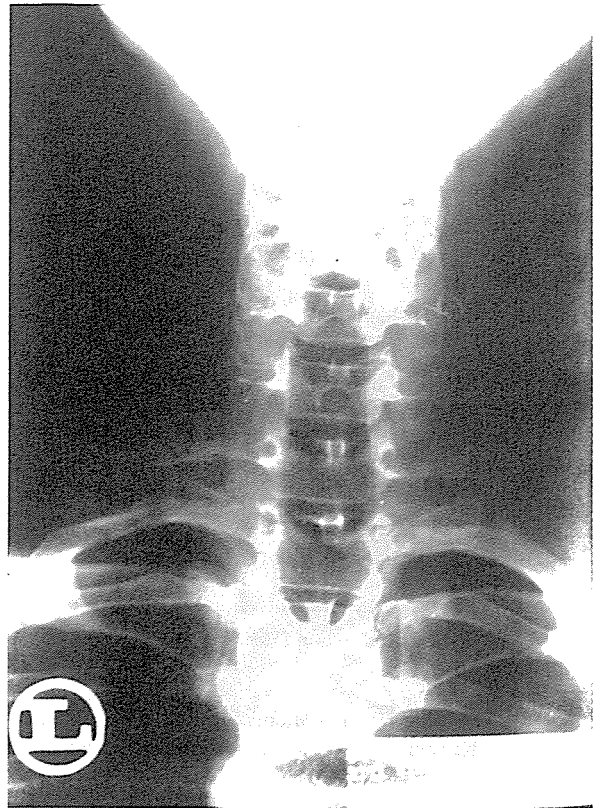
The roentgenogram of a patient with cervical rib on the left side and prominent transverse process of the seventh cervical vertebra on the right side.
